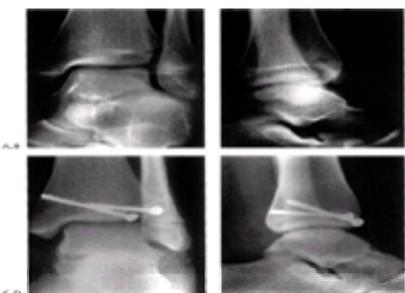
Transitional fracture. A: The anteroposterior radiograph shows displacement of the anterolateral distal epiphysis (Tillaux fracture). B: The lateral radiograph demonstrates anterior displacement and rotation of the fragment. C: Postoperative radiograph after open reduction and internal fixation with cancellous bone screws. D: Lateral radiograph. In this instance, the screws can cross the physeal line, because this injury occurred in an adolescent after the growth plate had begun physiological closure.
